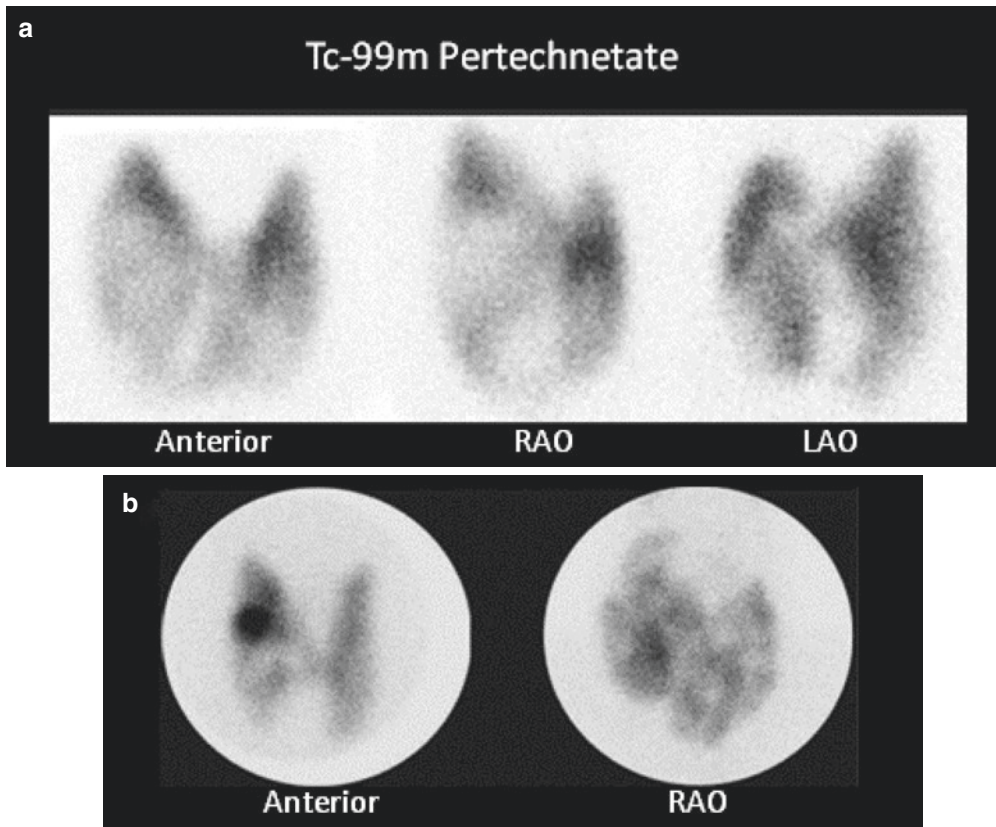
Multinodular goiter as it appears on scintigraphy. (a) represents multiple cold nodules a while (b) shows mixture of cold and hot nodules
